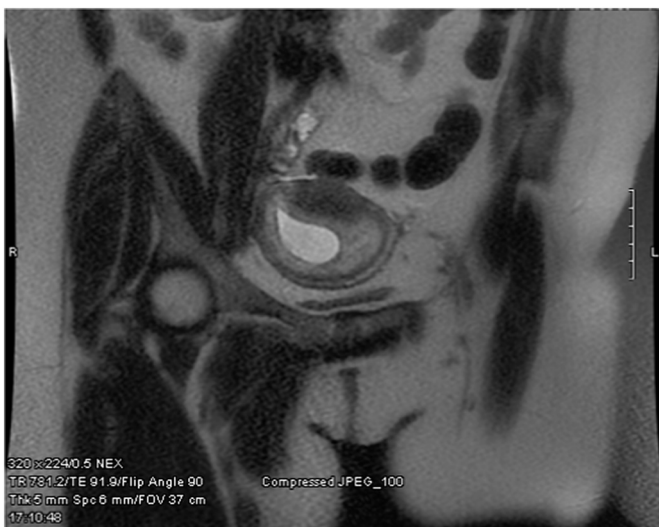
T2-weighted Coronal MRI demonstrating the asymmetric location of the gestational sac which extends into the right cornua.
